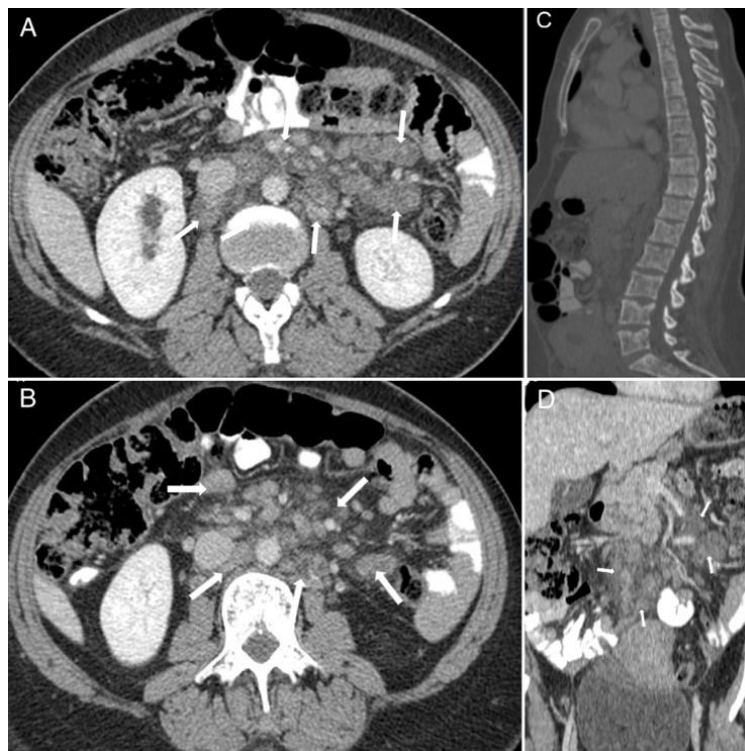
Postpartum CT examination
